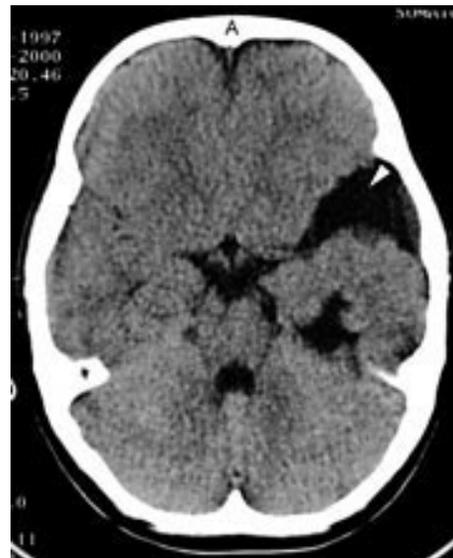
CT scan showing right temporal arachnoid cyst.
